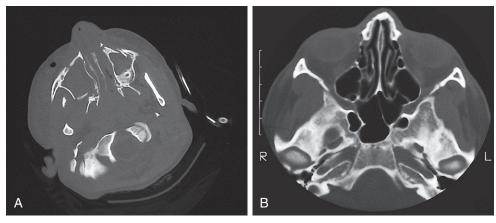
Le Fort III fracture. This 10-year-old girl was hit by a car while sledding. Clinically, she had bilateral raccoon eyes; severe facial edema with a mobile maxilla; and bleeding from the nose, mouth, and eyes. She had the constellation of fractures that constitutes a Le Fort III fracture and numerous other facial and skull fractures. A, CT cut shows multiple fractures involving the anterior, posterior, and medial walls of the maxillary sinuses. B, Bilateral zygoma fractures are evident in another cut.
